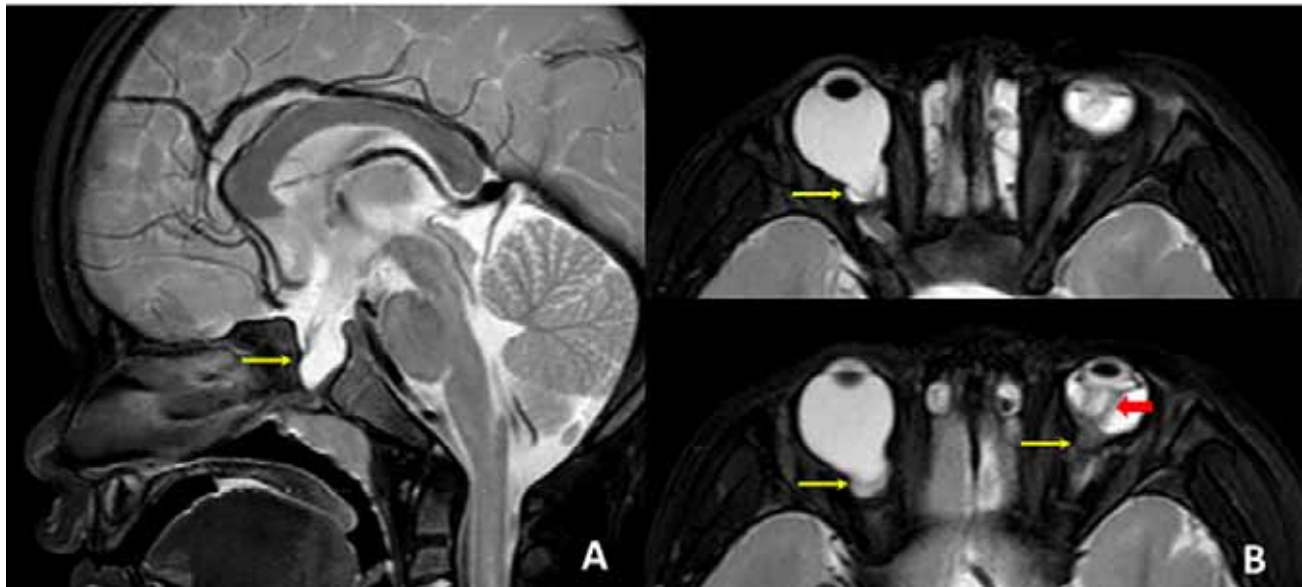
MRI of brain and orbit. (A) Sagittal T2 view shows midline defect of the floor of sella (arrow) with widened CSF-filled sellar turcica without definite herniation of brain tissue or meningeal sac. (B) Axial fat-saturated T2 of the orbit (top and bottom) demonstrates a funnel-shaped morphologic pattern of the optic disc (arrows) confirming the clinical diagnosis of bilateral MGDA and presence of hyposignal T2 retroretinal soft tissue along the Cloquet's canal in the left orbit likely persistent fetal vasculature (red arrow). (Colored figures are on page 47)
